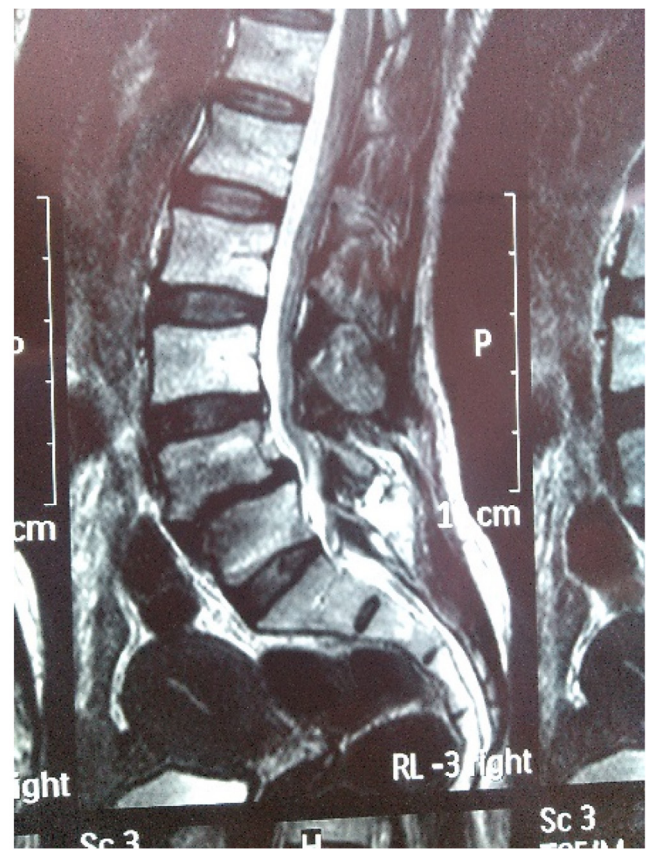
Lumbosacral MRI Showing L4/L5 spondylolisthesis.
